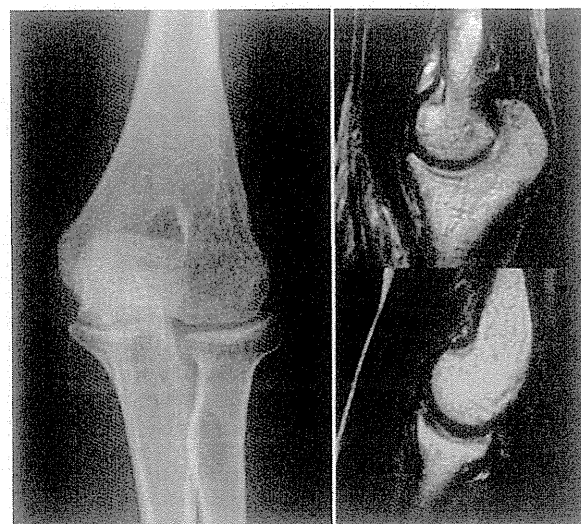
AP radiogram and MRI T2-weighted sagittal images of the left elbow obtained 2 years after the arthroscopic synovectomy show good congruity of the joint with remodelling of subchondral bone. No synovitis exists.
